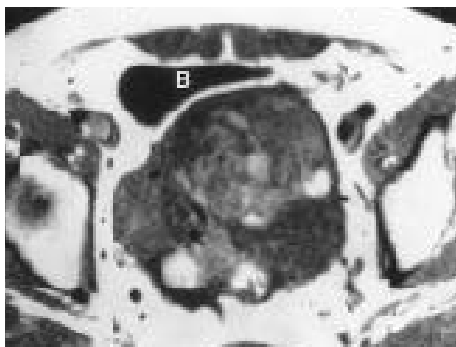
Axial pelvic MR images of left struma ovarii in a 65 year-old woman with clinical impression of polycystic ovarian disease due to past medical history of primary infertility (Case No. 3).
